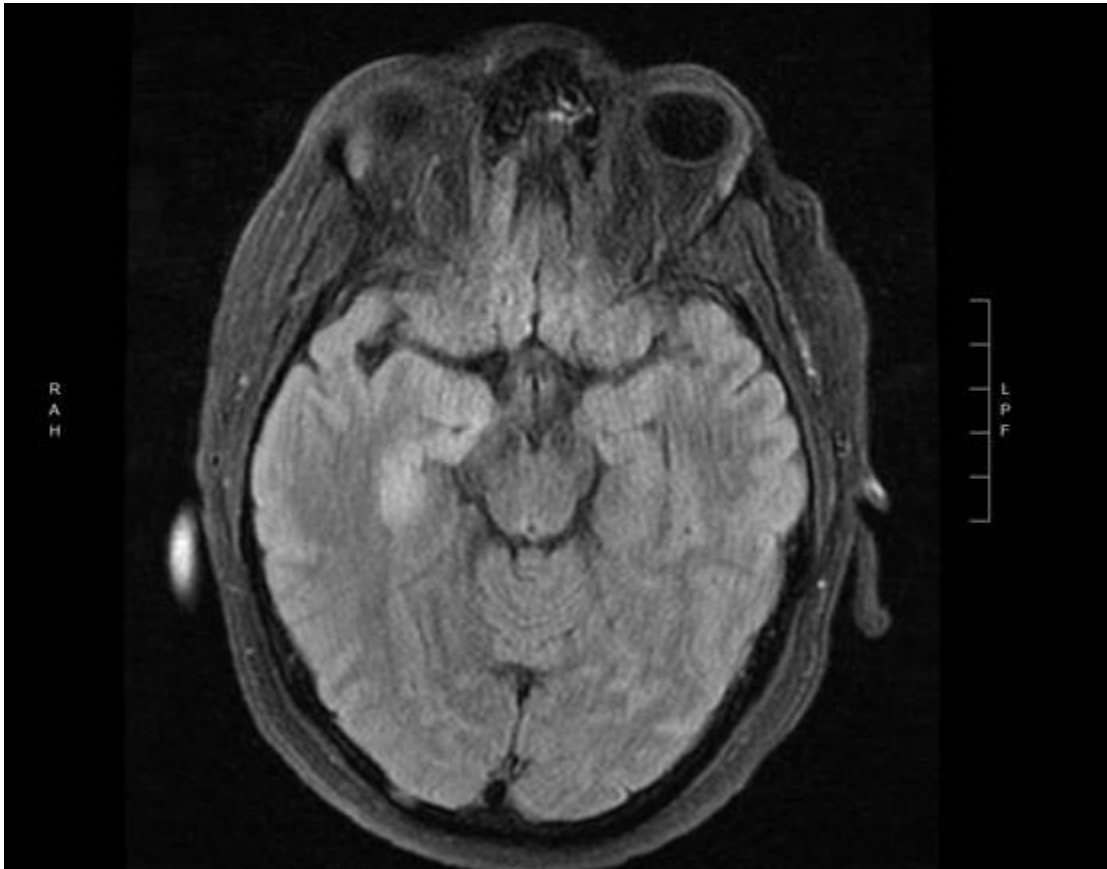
Brain MRI without contrast. Abnormal and asymmetric T2/FLAIR signal hyperintensity in the right amygdala and the entire right hippocampal formation. MRI, magnetic resonance imaging; T2/FLAIR, T2-weighted-fluid-attenuated inversion recovery.
